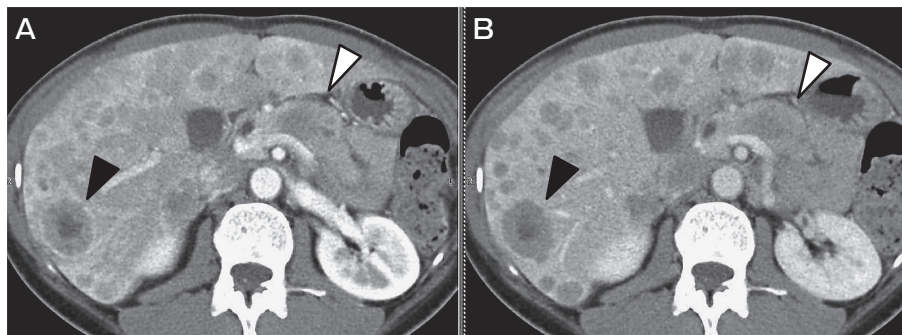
Contrast-enhanced CT scans on admission. Arterial phase (A) and portal phase (B) of the CT scans showed a 2.7-cm tumor with diminished contrast effect and an ill-defined border in the pancreatic body (white arrows), in addition to dilation of the main pancreatic duct in the caudal portion. Multiple tumors were also detected in the liver, showing ring-shaped enhancement in the early phase and washout in the late phase (black arrows).
